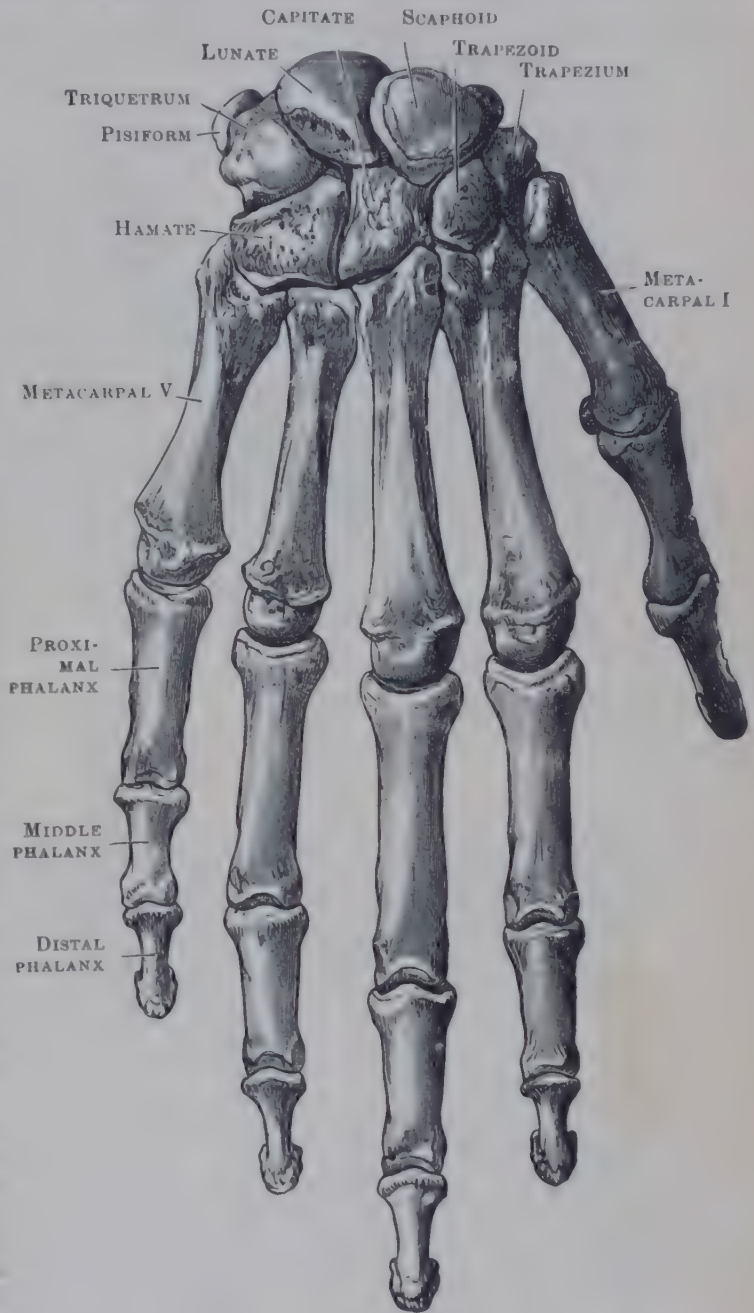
DORSAL ASPECT OF BONES OF RIGHT HAND.
